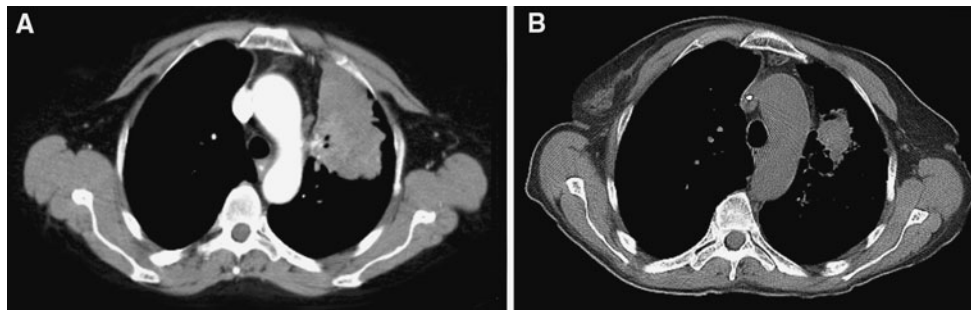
a CT scan with IV contrast at diagnosis demonstrating a large spiculated and lobulated mass in the left hilar region and left upper lobe, with encasement of local structures. b CT scan without IV
